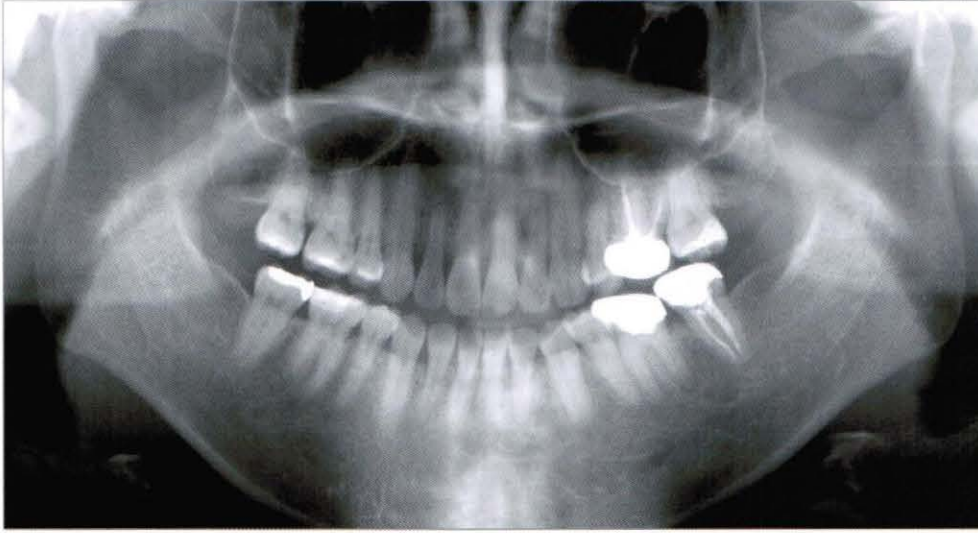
Panoramic radiograph at debonding (2006, 1,3)
